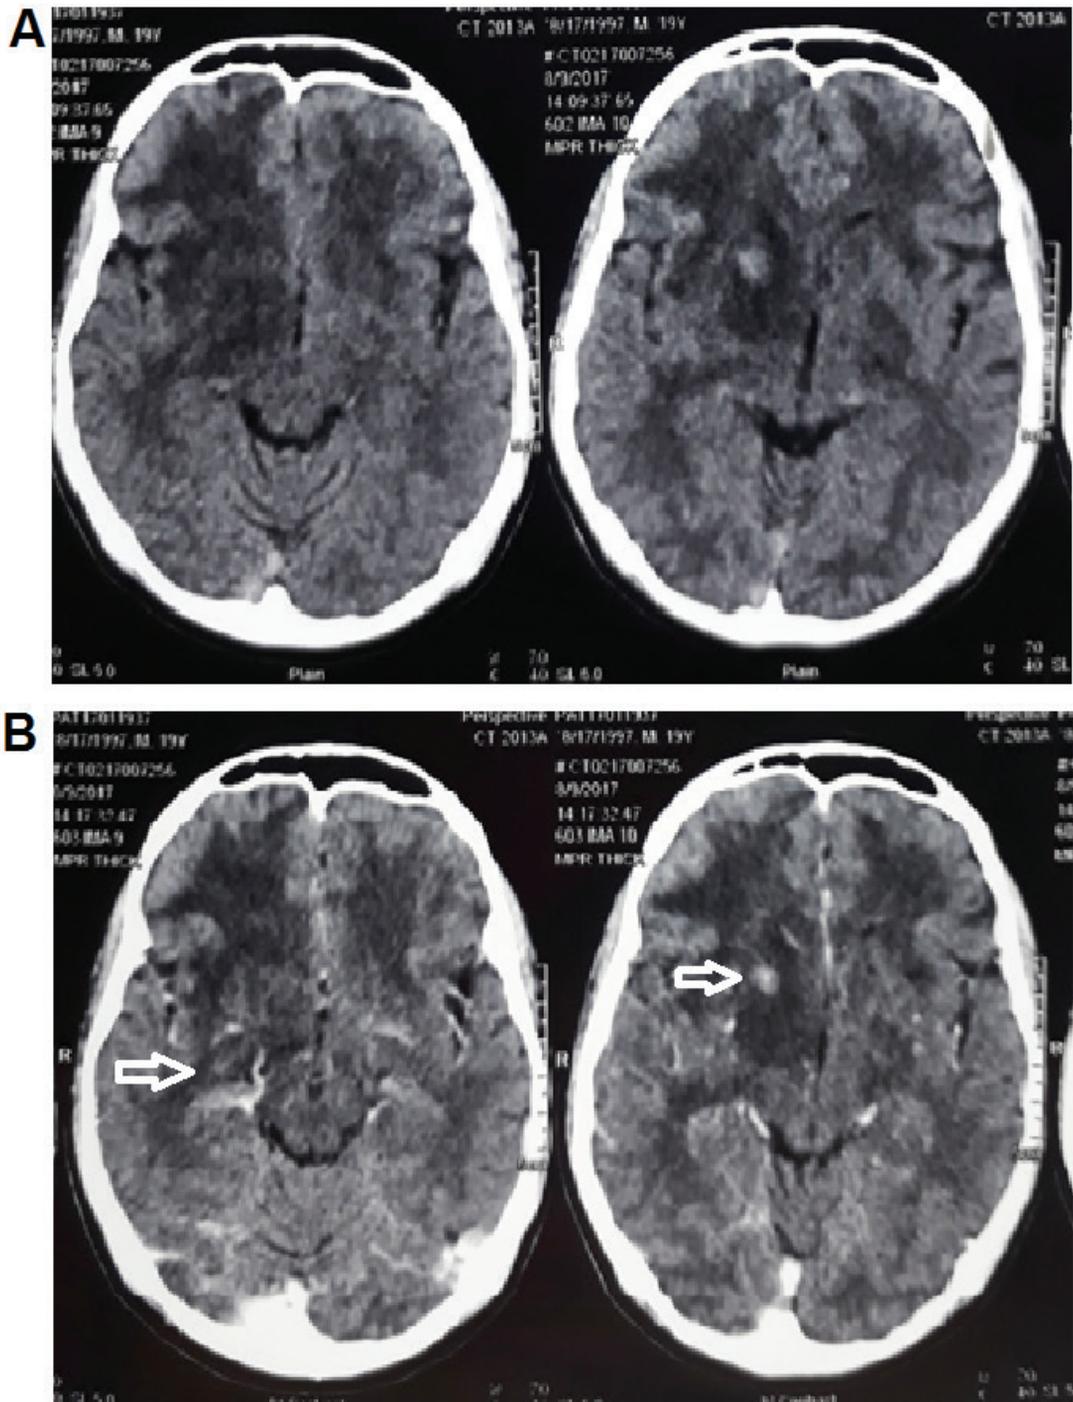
Plain and contrast-enhanced cranial CT scan in axial view. There is presence of almost symmetrical moderate low density changes or edema of the cerebral white matter especially in the frontal lobes including the internal and external capsules as well as edema in the caudate-lentiform nuclei and right anterior temporal white matter. Two (2) rim-enhancing nodules post-contrast in the putamen measuring 0.5 x 0.5 cm and 0.8 x 0.8 cm were noted (white arrow, left image). Another lesion (0.5 x 0.4 cm) is seen in the head of the caudate nucleus (white arrow, right image)
